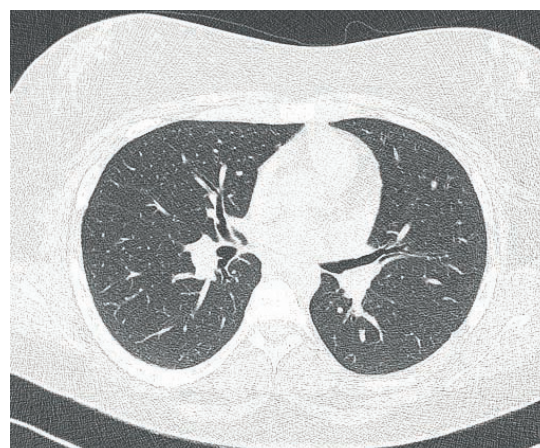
Chest Computer Tomography (CT) cross section.
